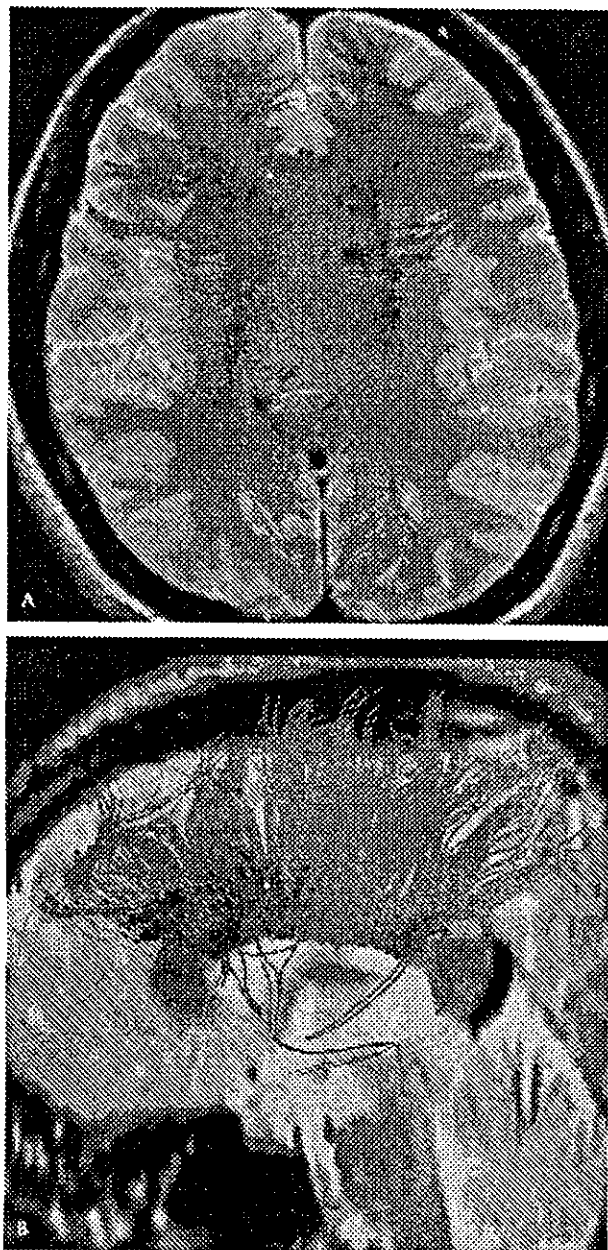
Diffusion tensor tractography through the body of the corpus callosum. The superoinferior (A) and lateral (B) views are overlaid on axial and sagittal T2-weighted fast spin echo images, respectively. The tracking lines through the body mainly passed along the upper course to the frontal or parietal lobe (shown in red). A smaller number of lines (shown in blue) ran along the lateral course, probably because of partial volume averaging in the corona radiata or semiovale center, where white matter tracts with a wide variety of directions were intermingled (eg, superior longitudinal fasciculus).
